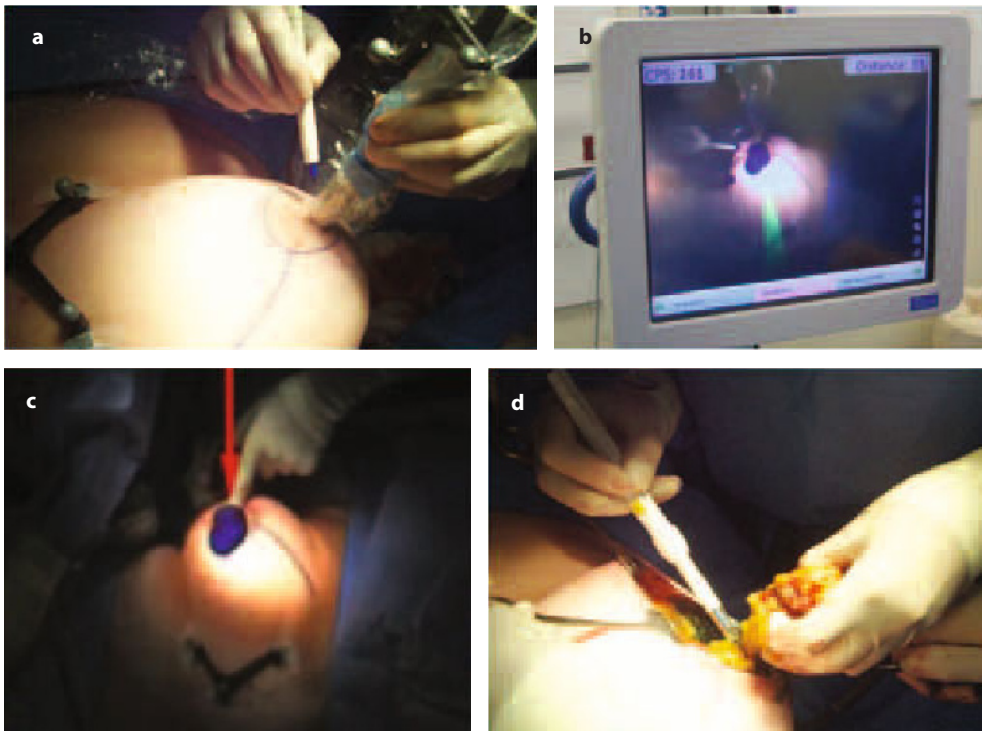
Freehand SPECT-based device system used for radioguided occult lesion localization (ROLL) in a patient with nonpalpable breast cancer. a Surgical approach for ROLL; the tracking device positioned on the patient's body is visible on the left. b, c Overlay of freehand SPECT 3D images on the video displays, with the red arrow in c indicating the site of the tumor. d Completion of lumpectomy guided by the freehand SPECT-based system
